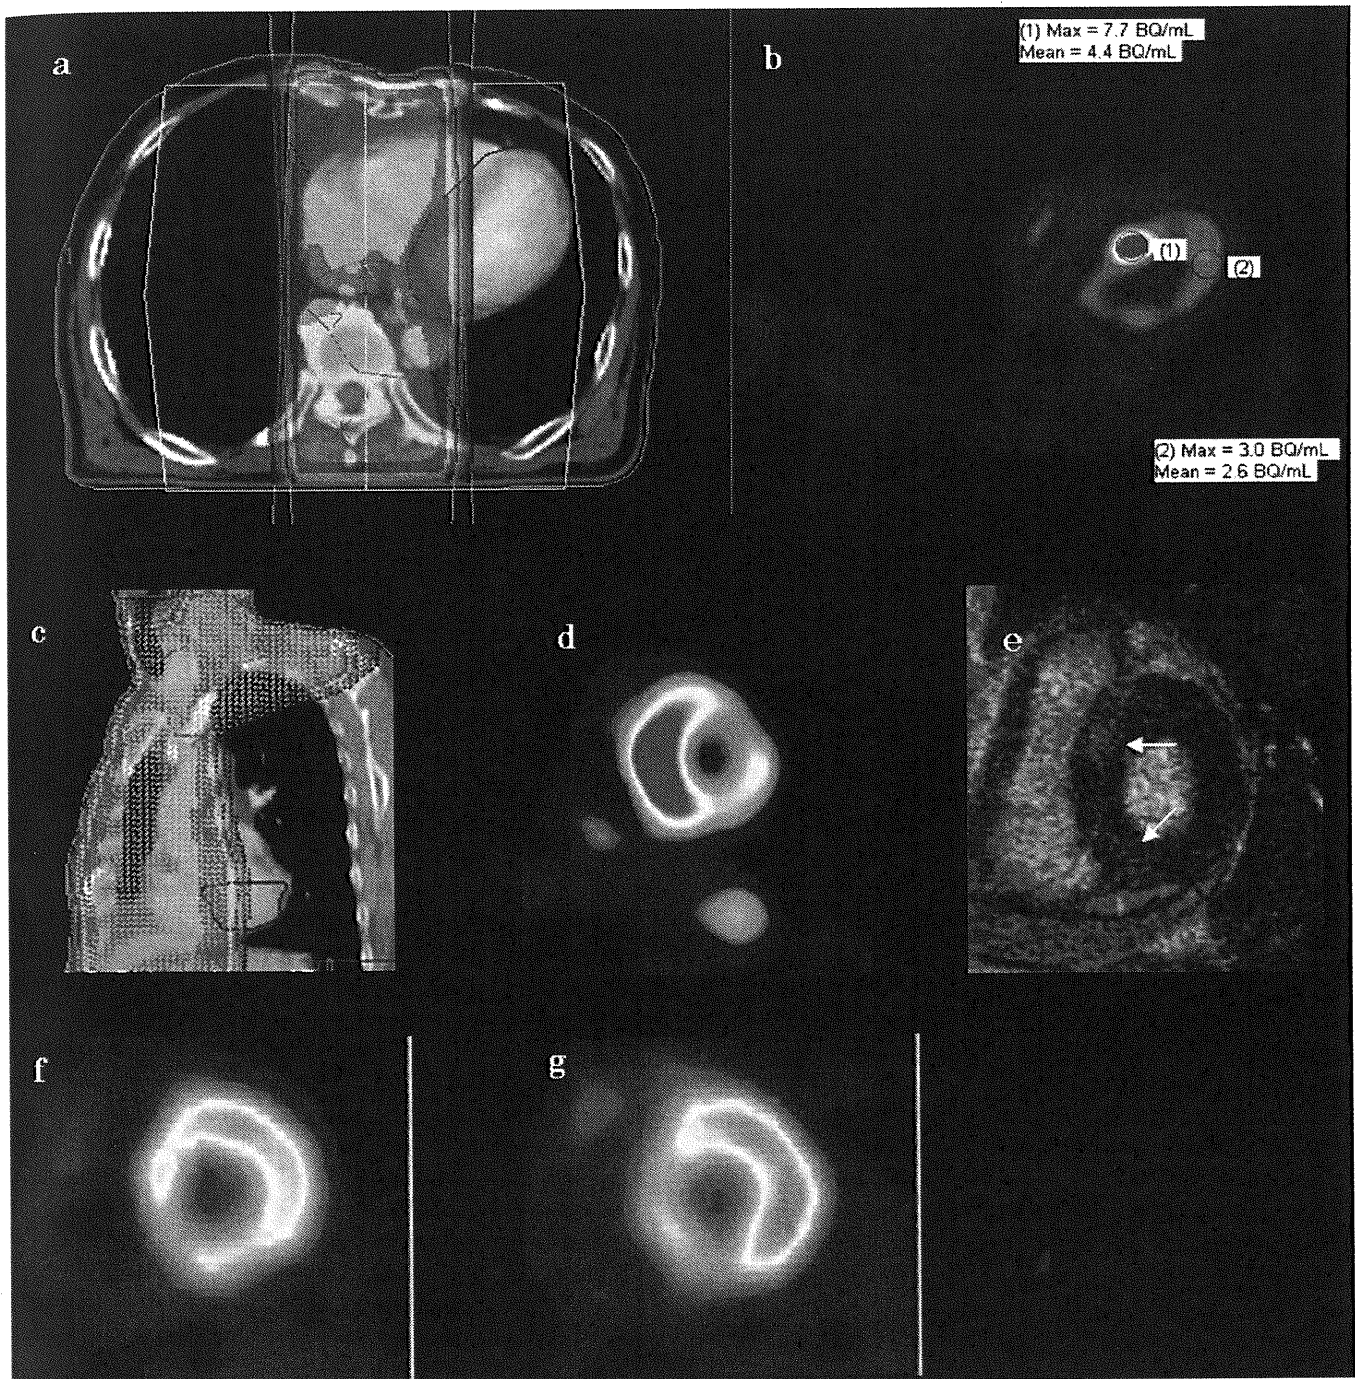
Images of Patient 2 (68-year-old male) at six months after chemoradiotherapy for esophageal cancer (T1N0M0). (a) Dose-distribution axial image. (b) F-fluorodeoxyglucose-positron emission tomography (FDG-PET) axial image. (c) Dose-distribution short-axis image. (d) FDG-PET short-axis image. (e) gadolinium-magnetic resonance image (Gd-MRI) in delay phase. (f)  $^{201}\text{TlCl}$  short-axis image. (g)  $^{123}\text{I}$ -BMIPP short-axis image. FDG-PET clearly shows high FDG accumulation in the base of the left ventricular myocardium corresponding to the irradiated field. Gd-MRI shows slight enhancement in the base of the septum (arrows).  $^{201}\text{TlCl}$  and  $^{123}\text{I}$ -BMIPP uptake are decreased markedly in the lesion.
